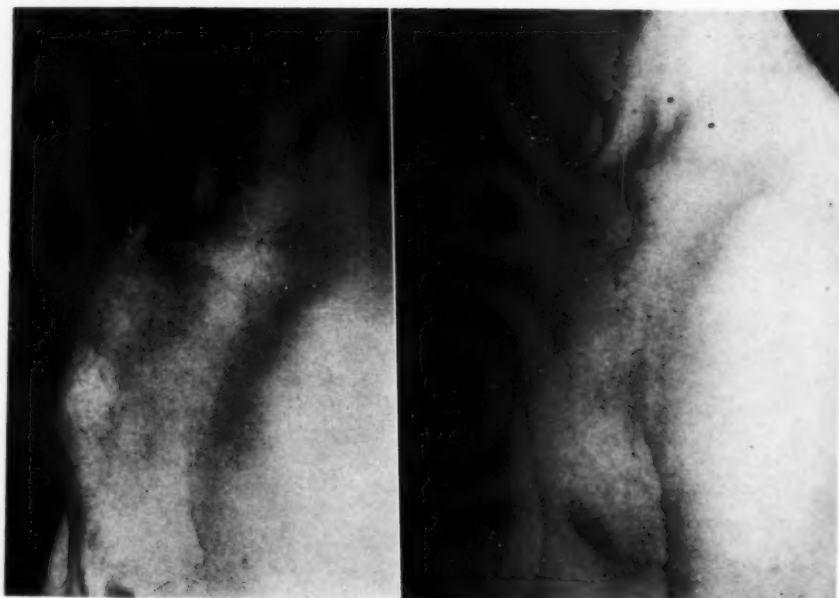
Adenocarcinoma: Metastasis in sternum before and after irradiation. This metastatic mass received roentgen therapy—4,000 r tumor dose—and two applications of radium needles, giving estimated doses of 6,000 and 8,000 gamma roentgens, respectively, with only moderate reduction in size.
